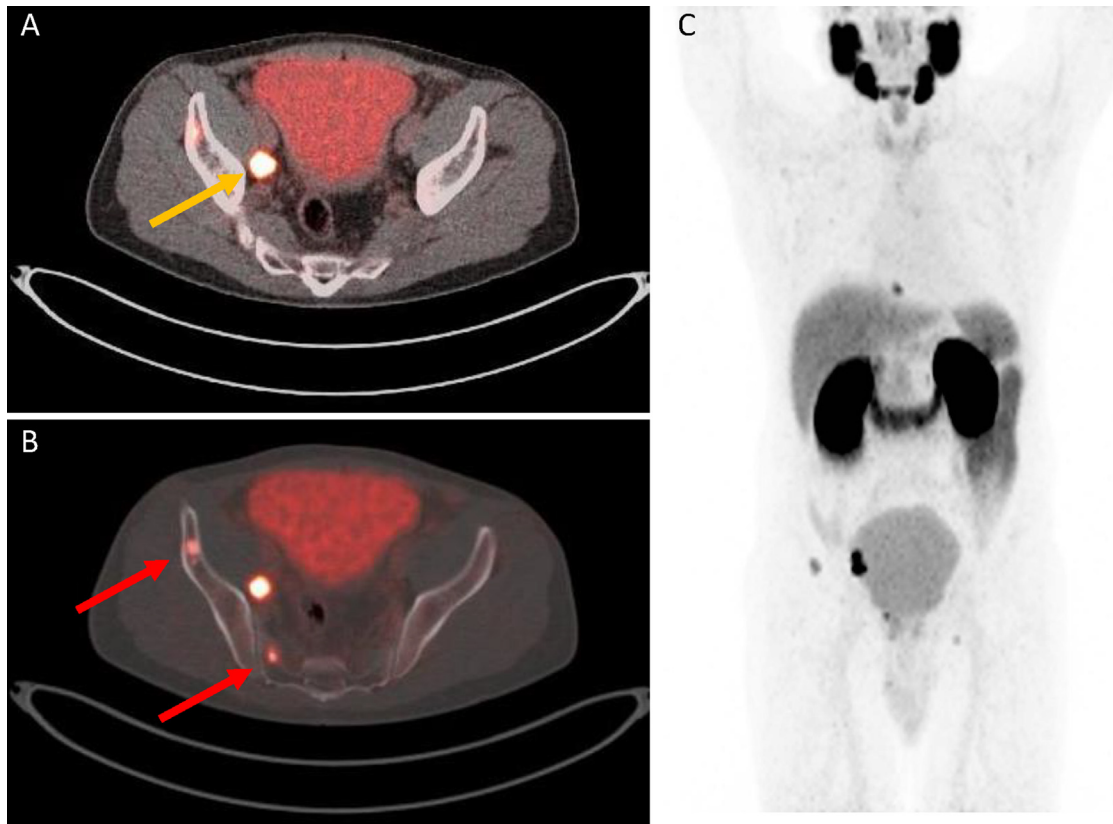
Images captured from a patient in LIGHTHOUSE. (A and B) Fused ^{18}F -rhPSMA-7.3-PET/CT images and (C) MIP (SUV 0–10) of a 66-yr-old patient initially presenting with unfavourable intermediate-risk PCa (Gleason 4 + 3, PSA 11.0 ng/ml, cT2), upstaged by findings of ^{18}F -rhPSMA-7.3-avid pelvic LN (Fig. 2A, yellow arrow) and multiple bone metastases, for example, in the sacrum (Fig. 2B, red arrows) and T10 vertebra (Fig. 2C, midline above the liver). The bone metastases were subsequently verified as true positive on CT. CT = computed tomography; LN = lymph node; MIP = maximum intensity projection; PCa = prostate cancer; PET = positron emission tomography; PSA = prostate-specific antigen; SUV = standardised uptake value.
